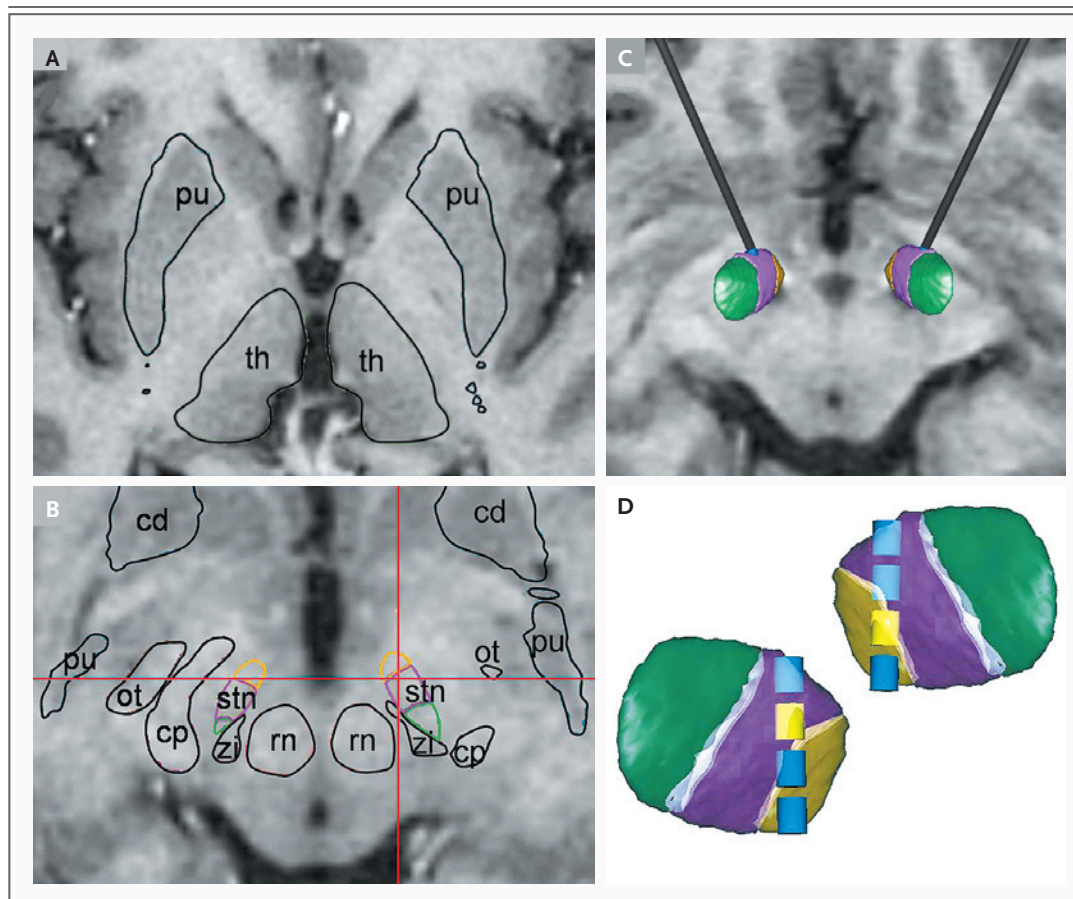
Atlas-Based Targeting on Preoperative MRI and Localization of the Electrodes and Contacts on Postoperative MRI in Patient 1.
